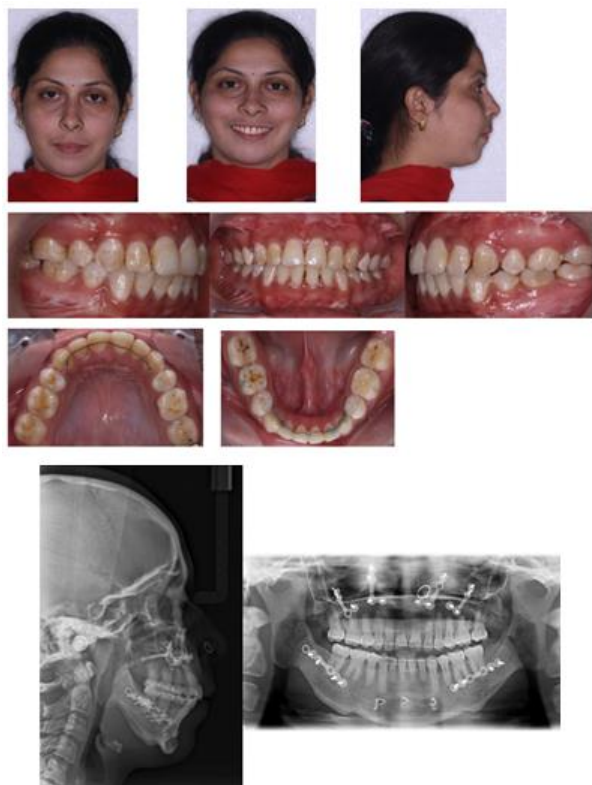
20 months follow up photographs and radiographs
